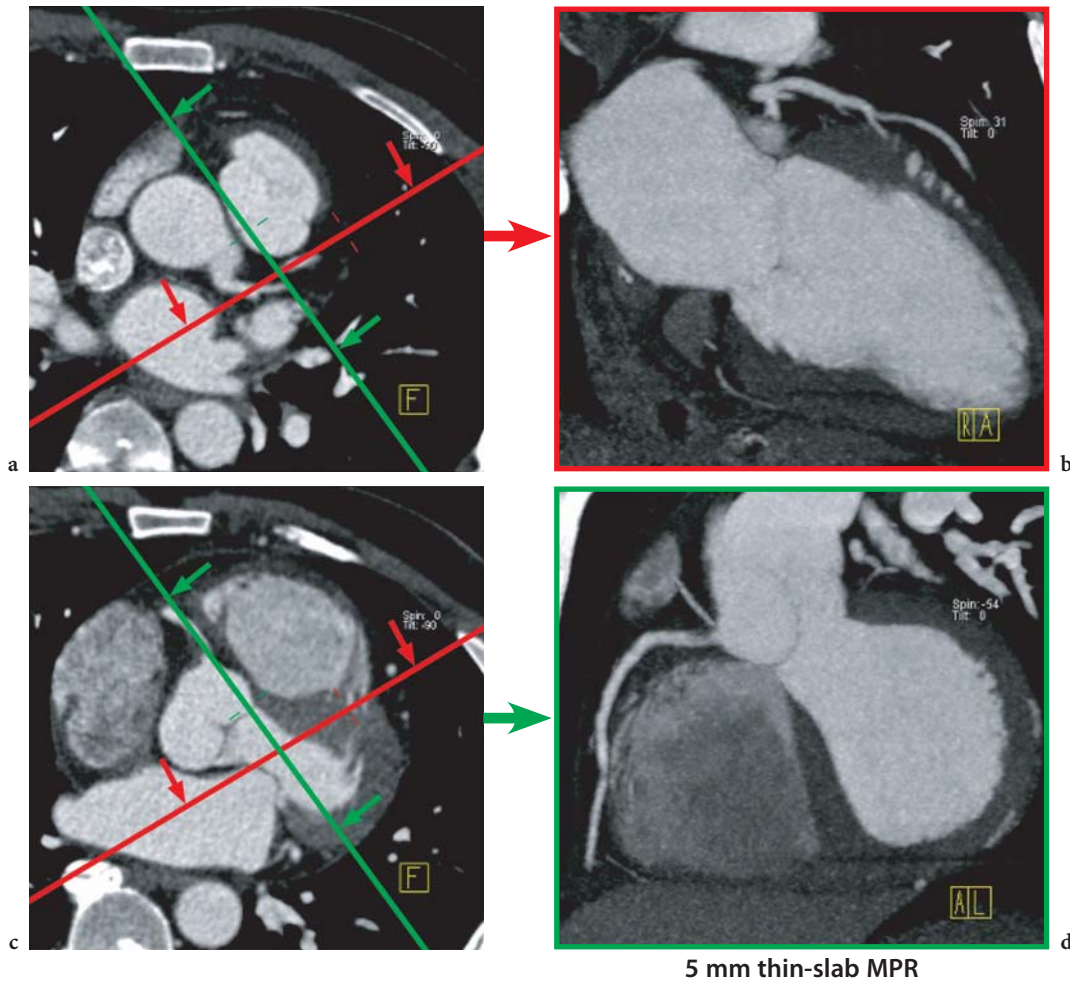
Maximum-intensity projection (MIP) for a coronary CT angiography examination displaying the proximal LAD (a, b) and proximal RCA (c, d). The axial images were acquired using a 64-slice CT scanner with 64×0.6 -mm slices per rotation and 0.75-mm slice width. MIP slab thickness was chosen to be 5 mm. The green and red lines in the axial images indicate the image planes of the MIPs. (Case courtesy of Erlangen University, Germany)
